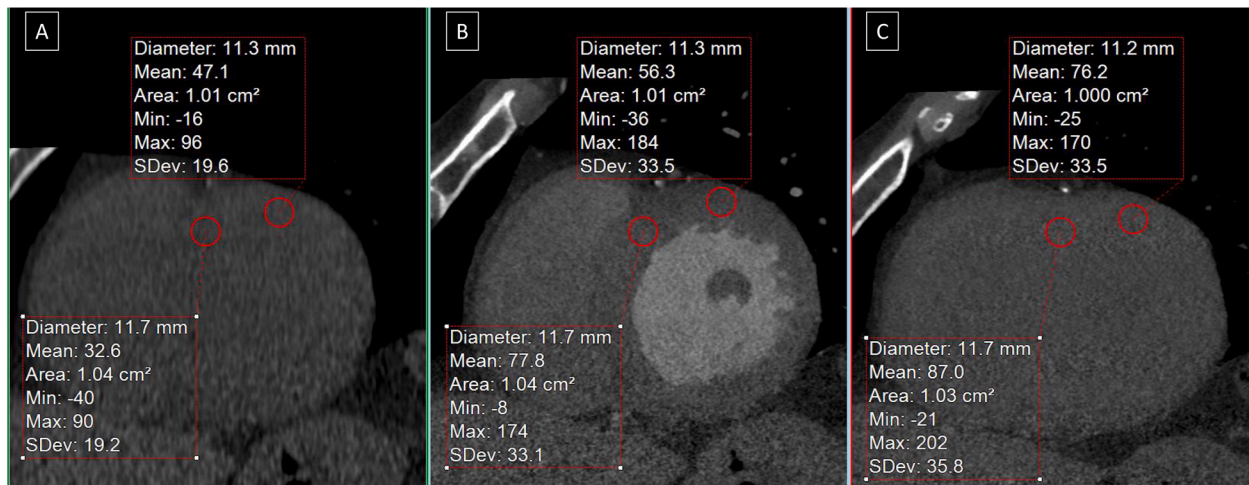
Assessment of ECV by single energy CT (SECT). Basal short axis left ventricle slices demonstrating sample volumes used in the calculation of ECV. Sample volumes are drawn in the arterial contrast phase image (B) and propagated automatically into the non-contrast (A) image and 5 min delayed image (C). Thus, non-contrast and delayed image sample volume Hounsfield units are derived for the same myocardial volume and ECV can be calculated.
